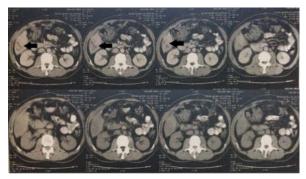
Computed tomography of the upper abdomen (05/13/16). Arrows: Decreased hypodense spots after 11 days of treatment.
